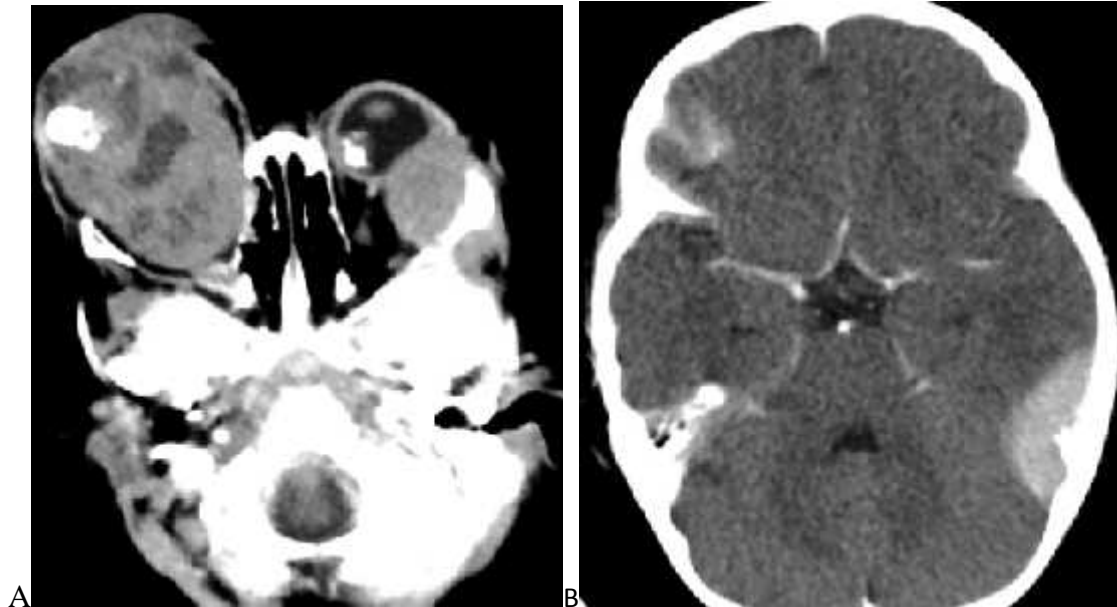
Axial soft tissue window contrast enhanced CT images of 2yrs old female patient diagnosed with bilateral retinoblastoma after she presented with proptosis of 1yr duration. A) Heterogeneously enhancing mass replacing the globe and involving all the subspaces of the orbit having internal areas of dense calcification. There is also focal lesion in the posteromedial wall of the left eye globe. There are homogeneously enhancing lesions involving extraconal space in the left orbit (A) and extra-axial space in the left occipitotemporal convexity (B) suggestive of intracranial metastasis.
